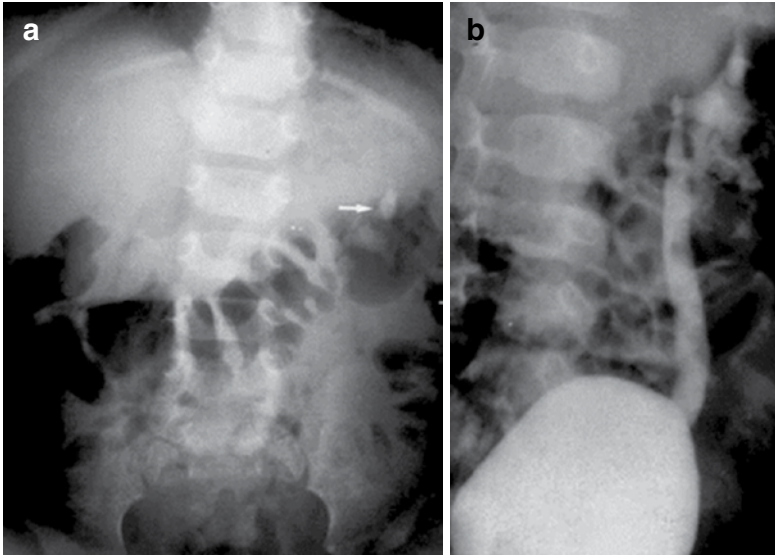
VUR and lithiasis. (a) Plain film of the abdomen showing the lithiasis. (b) VCUG: left grade II.
